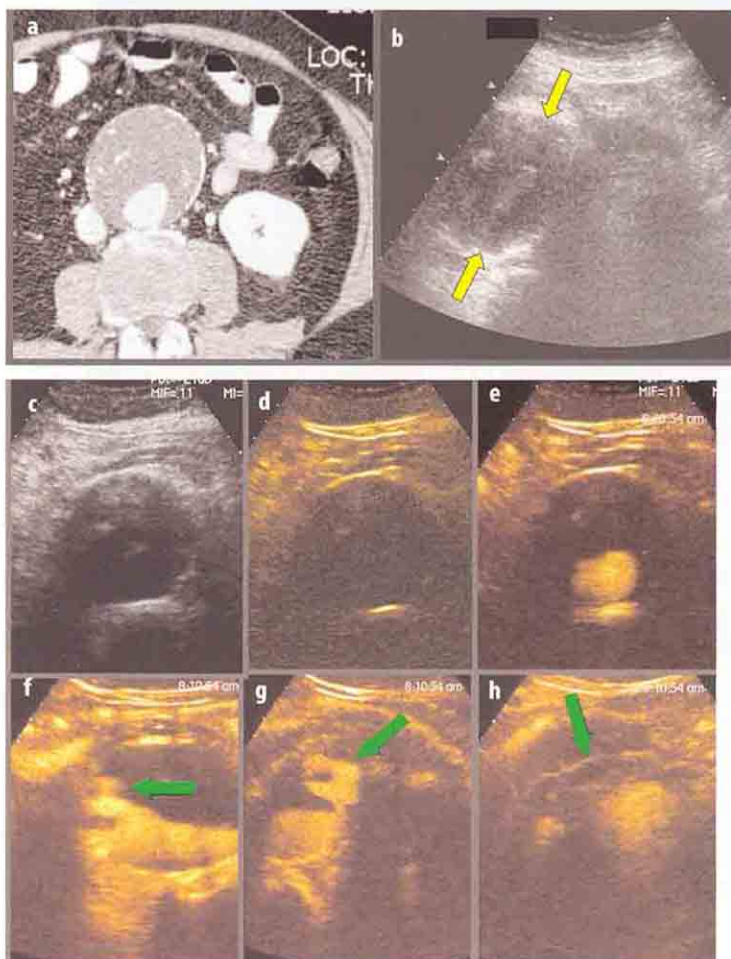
Rupturing abdominal aortic aneurysm.* a Transversal angio-CT scan. A wide parietal thrombus delimits a small flow chamber posteriorly located in this aneurysmatic sac. b Transversal scan, US. Marked inhomogeneous and hypoechoic appearance of peri-aneurysmatic tissues on the left side; the aneurysm has an identical caliber to the previous scan (yellow arrows). c-h Transversal scan, CEUS. After contrast injection, the flow lumen enhances; an irregular hyperechoic image branches off the flow lumen into an anterior thrombus (green arrows), corresponding to the dissection seat; a small amount of contrast agent is detectable inside the peripheral tissues, which are hypoechoic (h) due to the presence of a minimal blood supply in the peri-aneurysmatic haematoma
